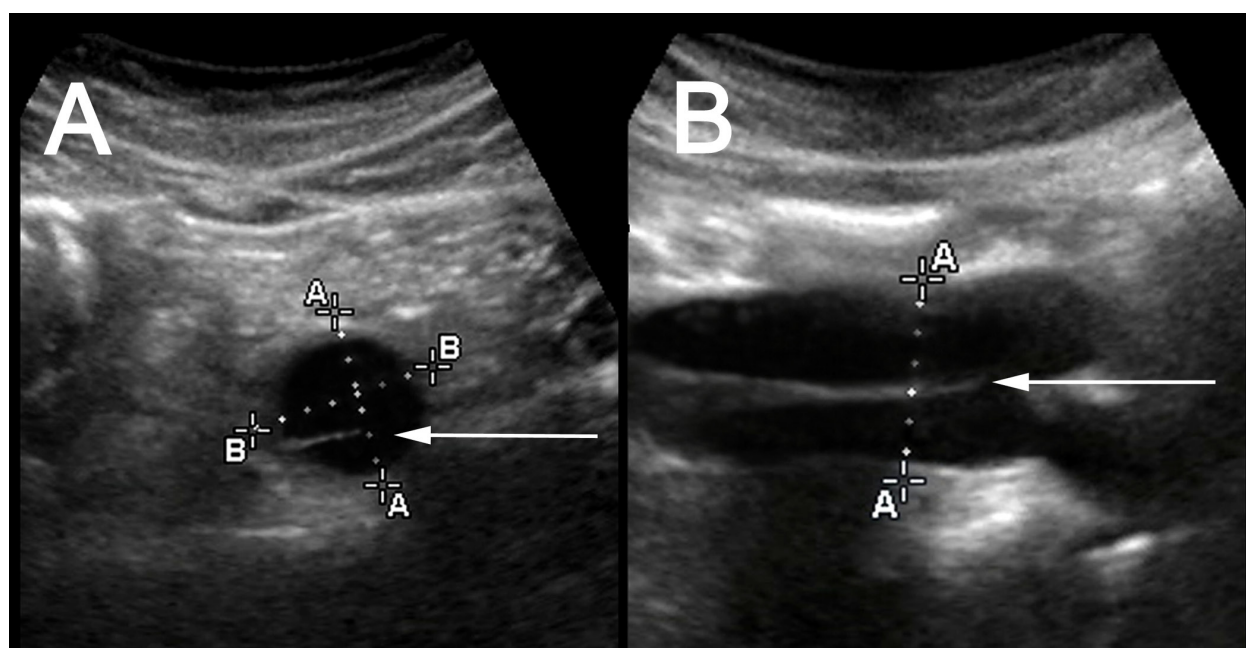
Emergency department ultrasound of the abdominal aorta in transverse (A) and longitudinal (B) axis.
